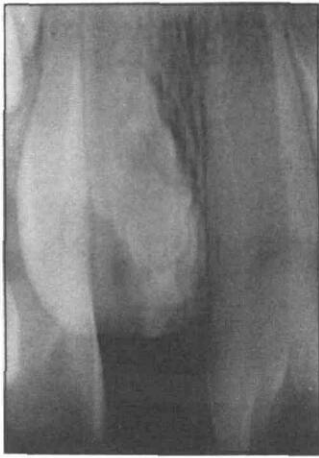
Periapical view of unerupted incisor with radiopaque mass adjacent to crown.
